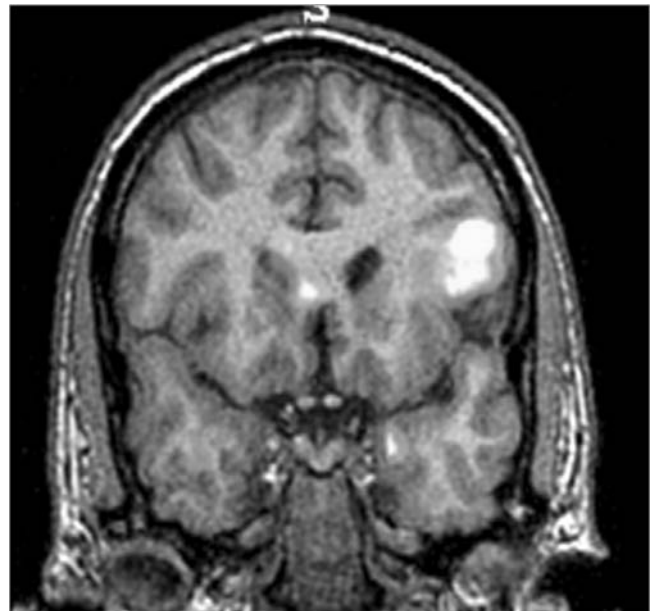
Ictal SPECT. Prominent left frontal hyperperfusion (right side of photo). MRI and routine EEG were normal. Intracranial monitoring confirmed the left frontal localization of seizures. Pathology was focal cortical dysplasia with balloon cells. The patient had been seizure-free for 9 years after surgery in 1998. Courtesy of Dr Gregory Cascino, Mayo Clinic. (See color insert).
